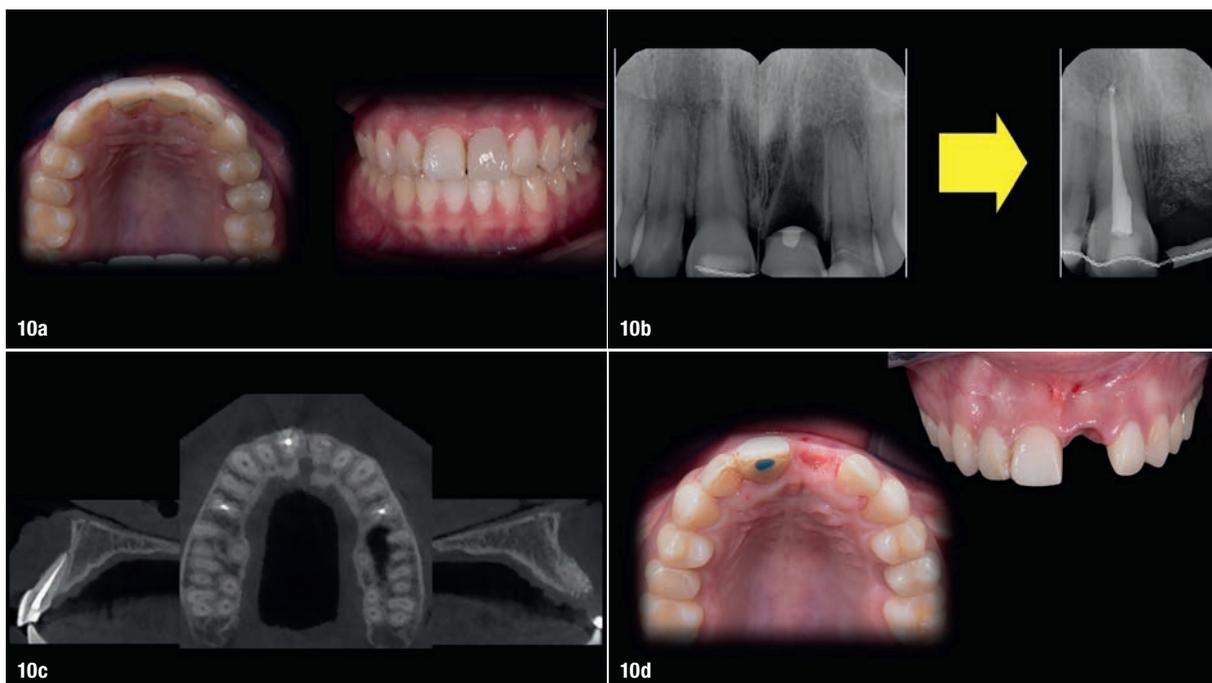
Aesthetic result of the first step. Fig. 10b: Bone regeneration. Fig. 10c: CBCT scan after five months. Fig. 10d: Preliminary soft-tissue conditioning.
